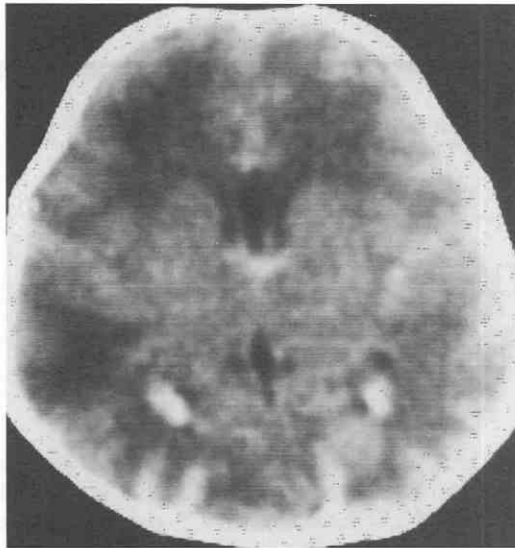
Immature myelination in a premature infant. CT scan, obtained at 1 month of age, demonstrates the typical lucency of incompletely myelinated white matter in premature infants. The internal capsules that myelinate first are not visible.
